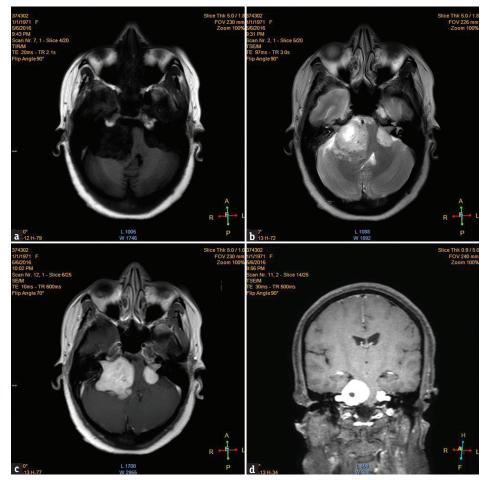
Magnetic resonance imaging brain (a) T1-weighted image showing hypointense tumor. (b) T2-weighted image showing hyperintense tumor. (c and d) Contrast image showing homogenously enhancing tumor in bilateral cerebellopontine angle
